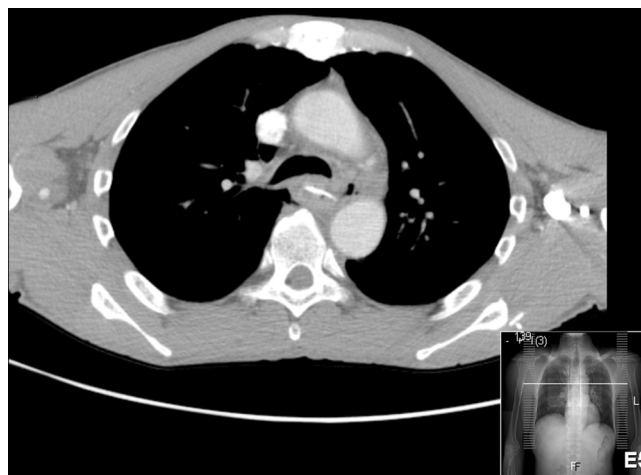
Chest computed tomography images. Horizontal view demonstrated the high-density foreign body lying transversely in the mid-esophagus. The ingested foreign body was about 2 cm in size. There was an abscess with 2 cm long at this level, with no evidence of mediastinitis.
